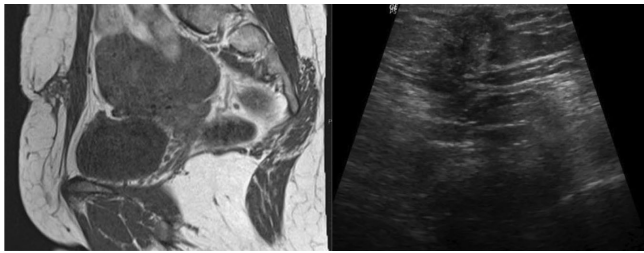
(A): T1W MRI reveals a subcutaneous hypointense lesion with mixed intensity on T2WI and FLAIR (not shown) in a case of scar endometriosis with a prior history of LSCS. Figure 3(B): Corresponding ultrasound image shows ill-defined subcutaneous lesion of mixed echogenicity.
